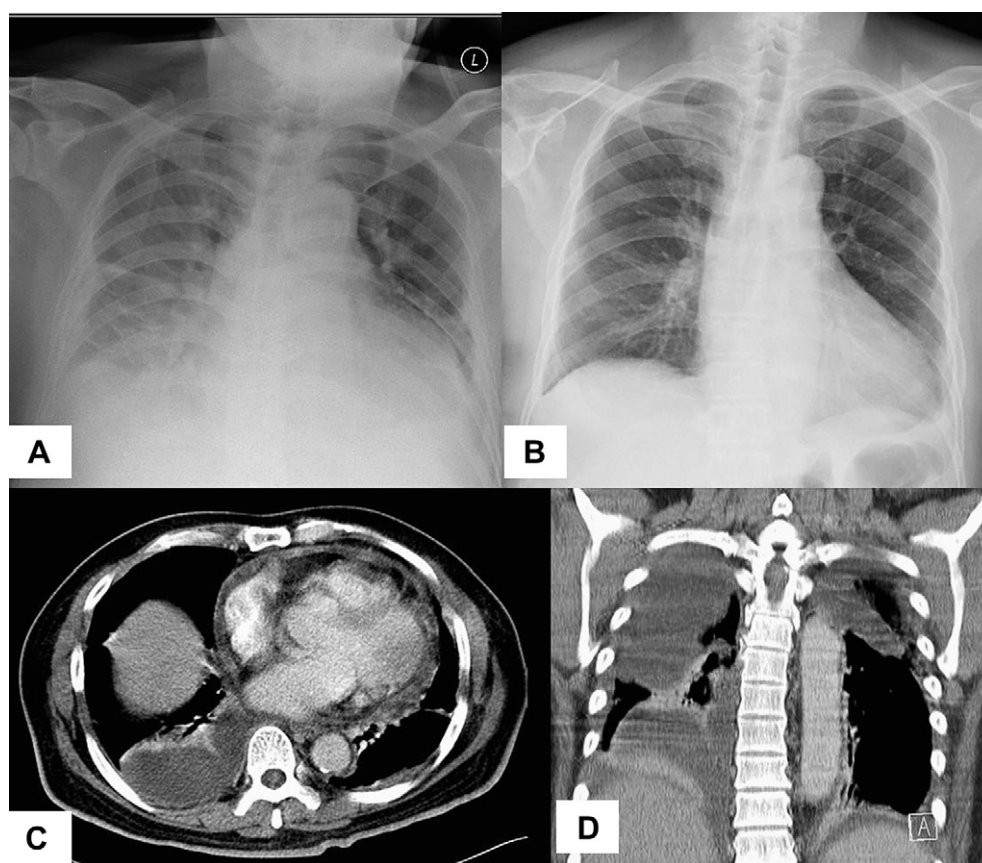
Chest X-ray and chest computed tomography before and after systemic steroid therapy. (A) Chest X-ray on this admission showing cardiomegaly and bilateral exacerbadated pleural effusion; (B) chest X-ray after right side decortication and systemic steroid therapy showing obvious improvement; (C, D) chest computed tomography showing lobulated pleural effusions over both lungs, more on the right side with consolidations and with ground glass opacities at bilateral lower lobes as well as cardiomegaly and some pericardial effusion.
